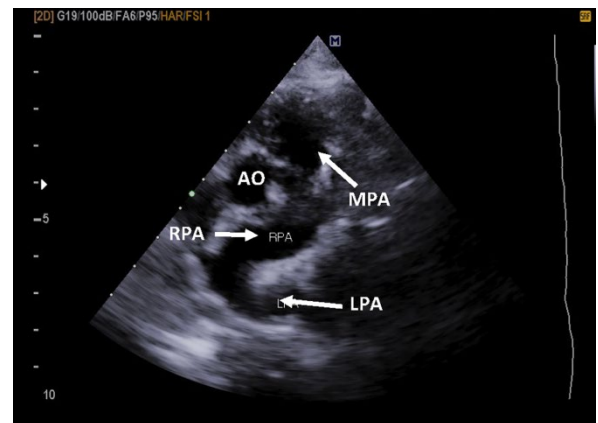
Echocardiography showing the abnormal origin of LPA from RPA.
